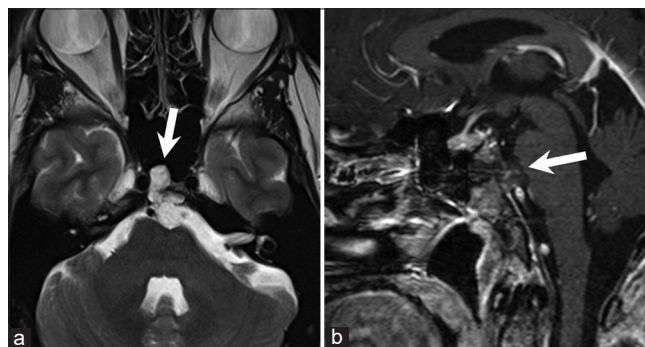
Chondroid chordoma. A 36-year-old male with chondroid chordoma. The tumor was incidentally found on head CT which was performed as part of work up for patient's headache (not shown). Axial T2W MRI image (a) and sagittal contrast-enhanced T1W MRI image with fat suppression (b) show a lobulated extra-axial T2 hyperintense, mildly enhancing mass centered at the superior aspect of the clivus (arrows) causing mild mass effect on the adjacent brainstem.
